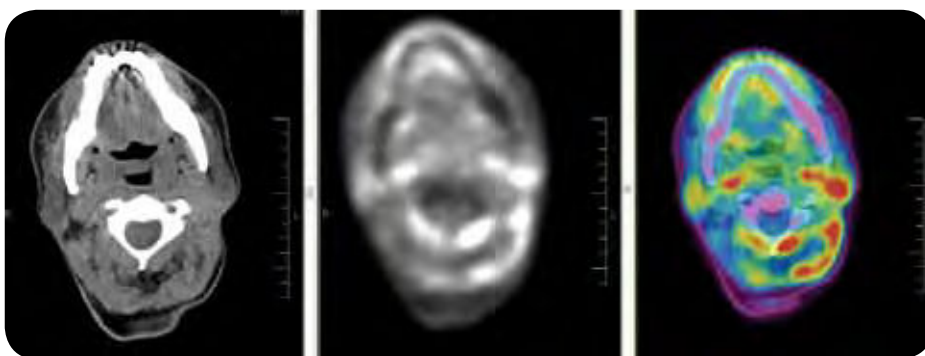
Left-Axial CT at level of body of mandible, soft-tissue window. Middle-FDG/PET showing increased uptake on left parotid and cervical lymph nodes. Right-FDG/PET/CT merged images, helps to localize the areas of increased uptake, in left parotid tail adenocarcinoma. (Image courtesy of Todd Stultz, MD, DDS, Cleveland, Ohio.)
